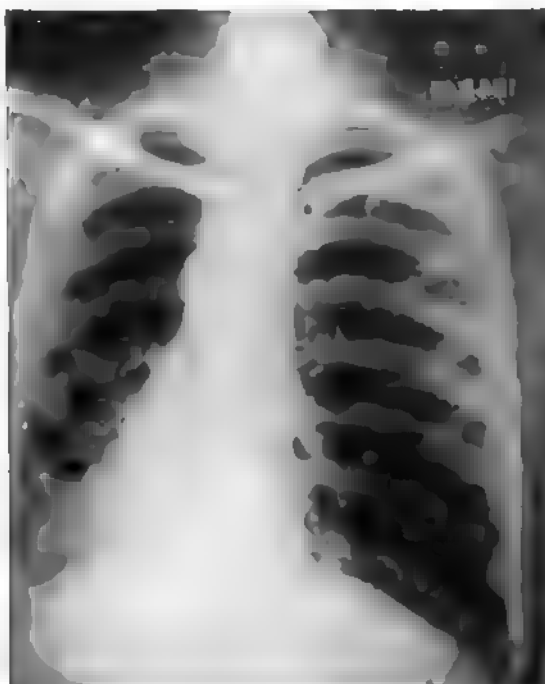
(154,501.) Roentgenogram, Case 4. Unilateral basal cylindric and sacular bronchiectasis. Type suitable for excision.
